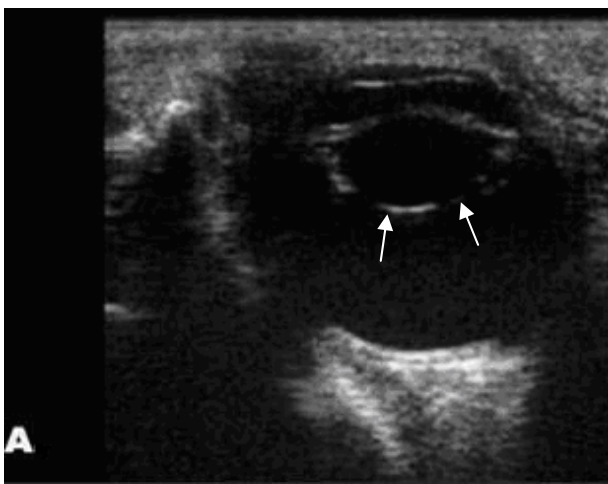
Ultrasonography image. A: Ultrasonography image (18 MHz linear probe) showing lens with thin hyperechoic lines (arrows) indicating early cataract changes. B: Ultrasonography image (7.5 MHz linear probe) showing hyperechoic rim around lens representing cortical cataract. Focal hyperechoic area in lens represents incomplete cataractous involvement. C: Ultrasonography image (18 MHz linear probe) showing nucleus echogenically enhanced, which is asymmetric but nearly complete. D: Ultrasonography image (18 MHz linear probe) showing margins of hyperechoic lens and lens with reduced thickness and wrinkled capsule (arrows) due to cortical reabsorptions
